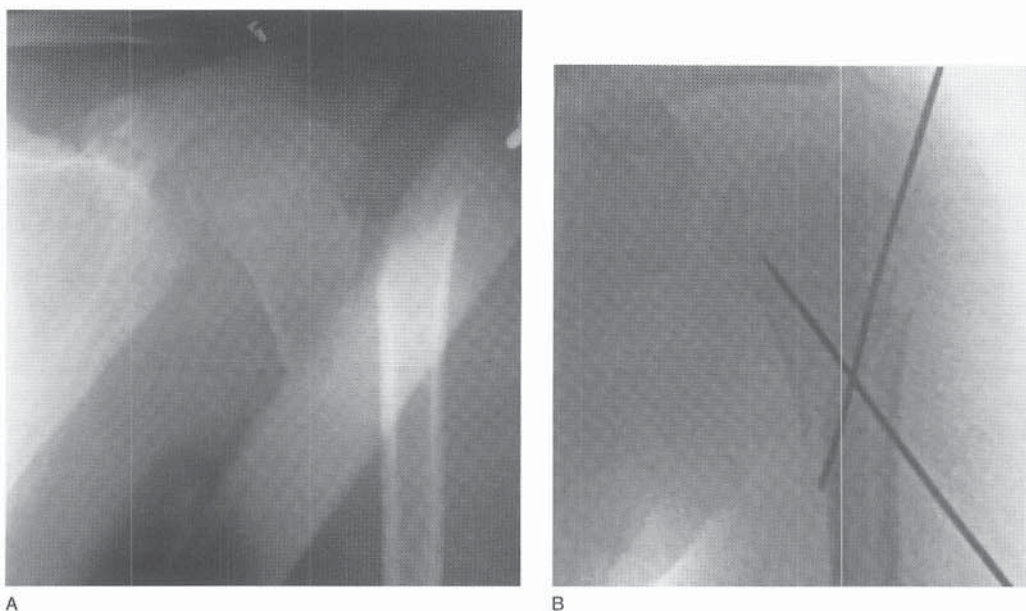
A, AP radiograph of a displaced proximal humeral metaphyseal fracture. B, AP radiograph obtained following closed reduction and percutaneous pin fixation. Fracture stabilization eases nursing care in the polytraumatized patient.
